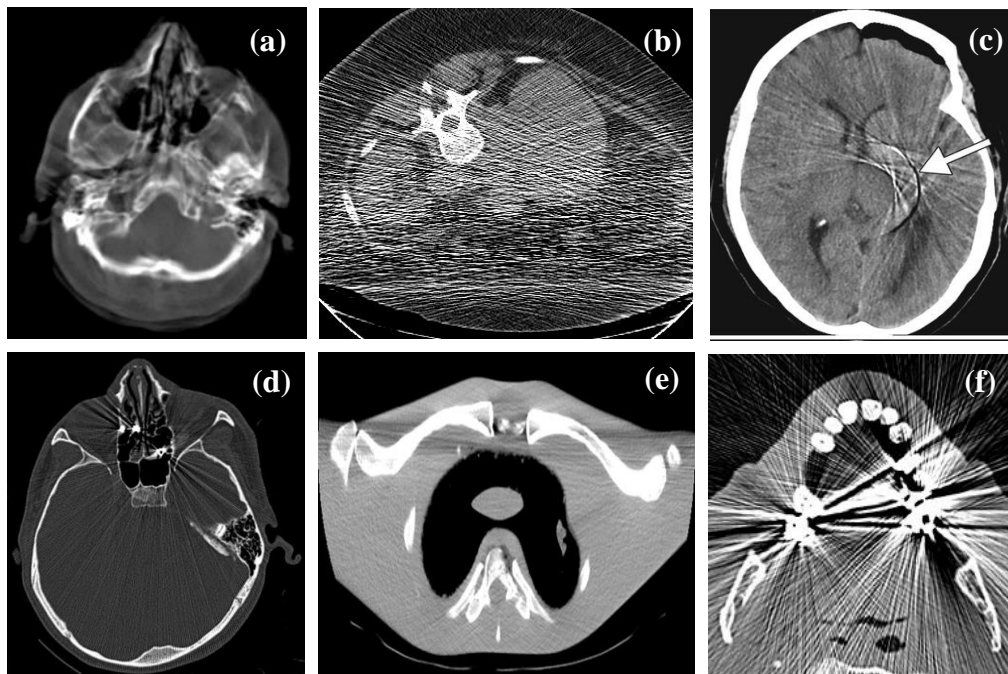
Artifacts in CT (a) patient motion, (b) Noise, (c) ring artifact, (d) streak artifact, (e) streak artifact due to photon starvation, (f) metal artifact (Boas et al., 2012).
